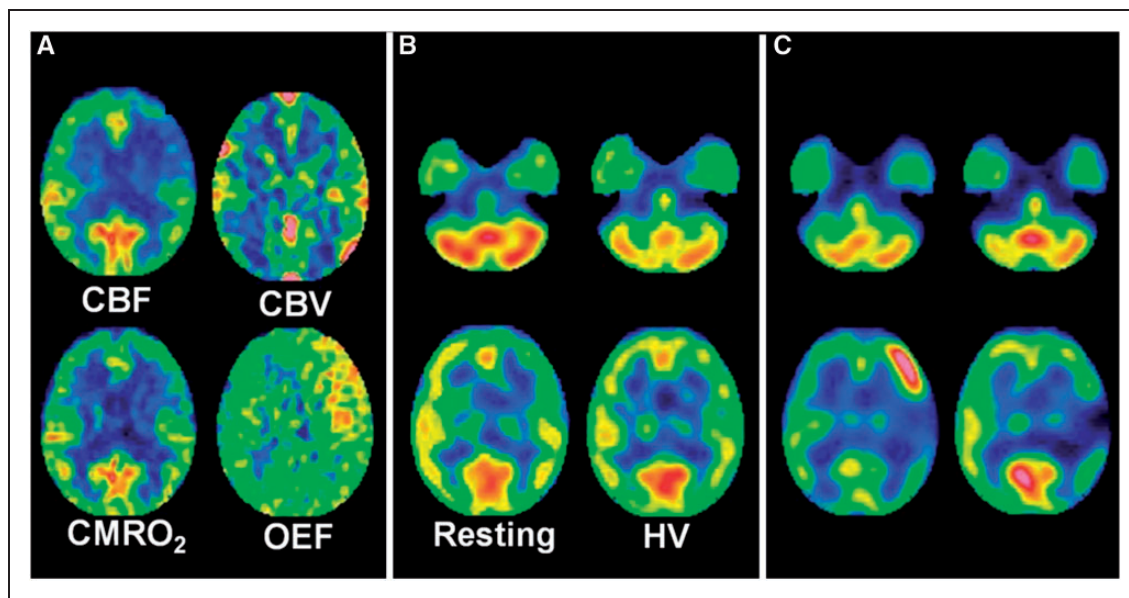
A 52-year-old woman with transient ischemic attacks of right hemiparesis and motor aphasia due to moyamoya disease. (a) Preoperative ¹⁵O gas positron emission tomography images show a decrease in cerebral blood flow (CBF) and an increase in cerebral blood volume (CBV) in the left precentral and central regions where cerebral metabolic rate of oxygen (CMRO₂) and oxygen extraction fraction (OEF) are slightly decreased and markedly increased, respectively. (b) Preoperative Technetium-99 m-labeled (^{99m}Tc) ethyl cysteinate dimer (ECD) single-photon emission computed tomography (SPECT) images at rest (left) show a decrease in tracer uptake in the left precentral and central regions relative to that in the left cerebellar region. This difference in tracer uptake is decreased on ^{99m}Tc-ECD SPECT images with hyperventilation challenge (right). The left-to-right precentral and central differences in tracer uptake are also decreased on ^{99m}Tc-ECD SPECT images with hyperventilation challenge when compared with those at rest. (c) N-isopropyl-p-[¹²³I]-iodoamphetamine (IMP) SPECT images one day after arterial bypass surgery reveal a focal increase in CBF in the left precentral region perfused by an anastomosed M4 of the left middle cerebral artery (left). Aphasia developed three days after surgery and propofol coma continued for five days. Right hemiparesis developed after recovery from this coma. This hemiparesis remained at one month after surgery when ¹²³I-IMP SPECT images demonstrate resolution of a focal increase in CBF in the left precentral region and development of a focal decrease in CBF in the left central region (right).
